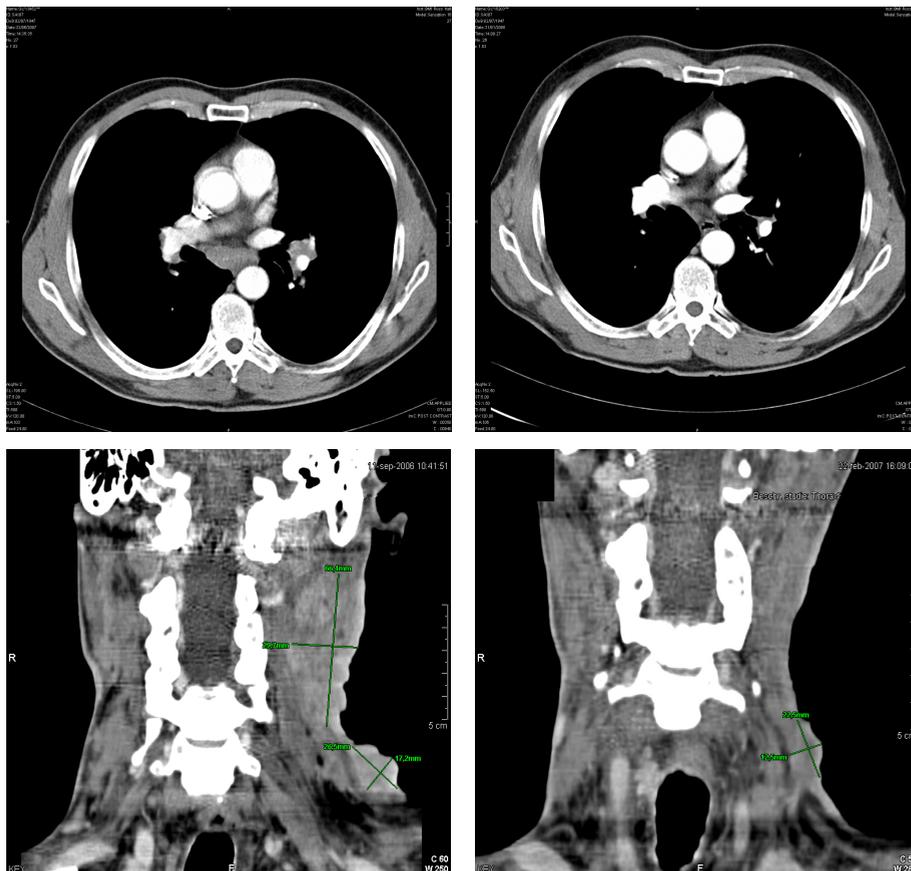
CT Scans of patients treated with E7080. Upper figures: CT evaluations of a patient with metastatic melanoma before (left) and after (right) 8 cycles (32 weeks) of treatment with E7080. This patient had an overall reduction in total tumor burden of 73%. Lower figures: CT evaluations of a patient with a nasopharynx carcinoma, before (left) and after (right) 6 cycles (24 weeks) of treatment with E7080. This patient had an overall reduction in total tumor burden of 41 %.
